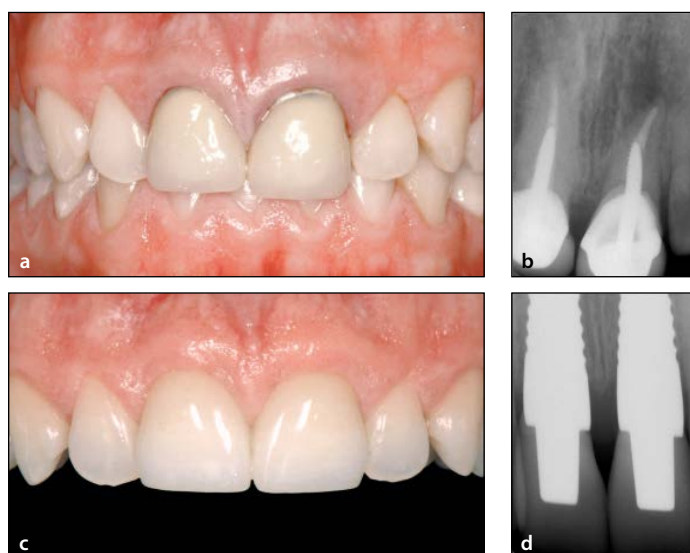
(a) Two failing central incisors with root canals. (b) Preoperative radiograph confirming root fractures. (c and d) Immediate upper central incisors at 15 years follow-up.
